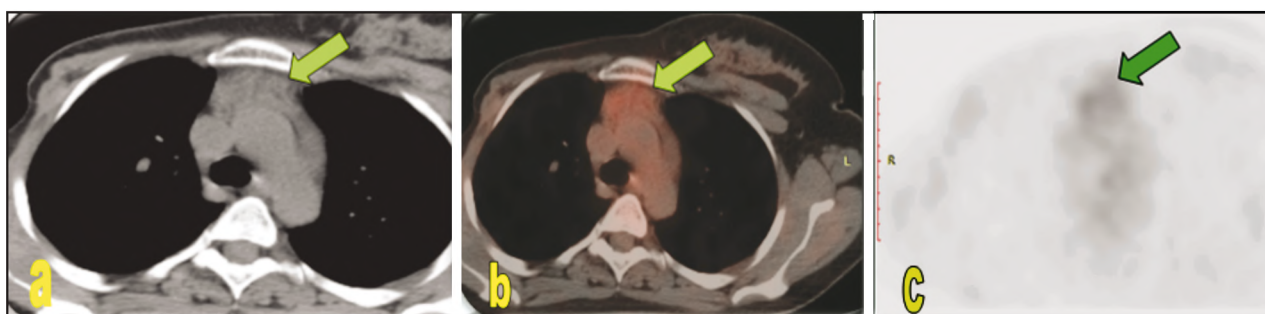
PET CT study for Female patient 39 year old presented with palpable supra-sternal swelling & discomfort. Axial CT Chest with fused PET images (A,B,C) showing fairly defined anterior mediastinal soft tissue lesion with low grade metabolic activity, SUVmax=3.3 (Arrowed). PET/CT Diagnosis: Benign looking lesion. Pathology revealed: Thymic hyperplasia.
